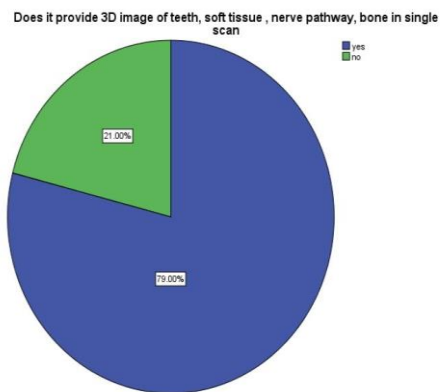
Pie chart shows the knowledge about CBCT providing 3D imaging in single scan . in that 79% said it can be seen in a single scan and 21% said it cannot be seen in the single scan. Blue indicates yes and no indicate green.
